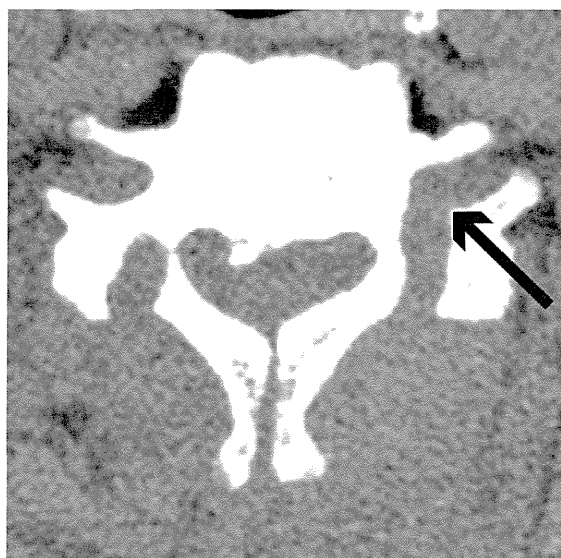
Postoperative CT of a case with vertebral artery injury due to an excessively deep trough (arrow).
